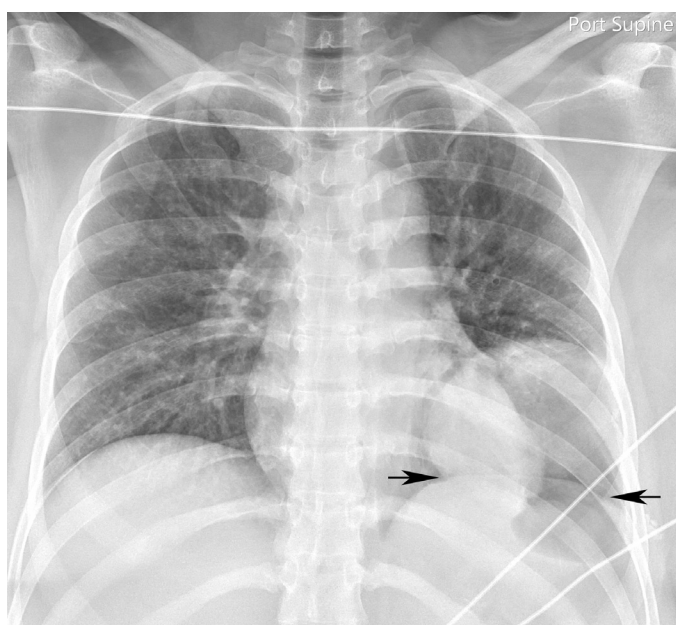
■ Anteroposterior (AP) supine chest x-ray. Diaphragmatic rupture: “collar” sign with narrowing of the left juxtadiaphragmatic mass (*black arrows*) with the spleen and stomach protruding through the left hemidiaphragm defect into the left hemithorax.
